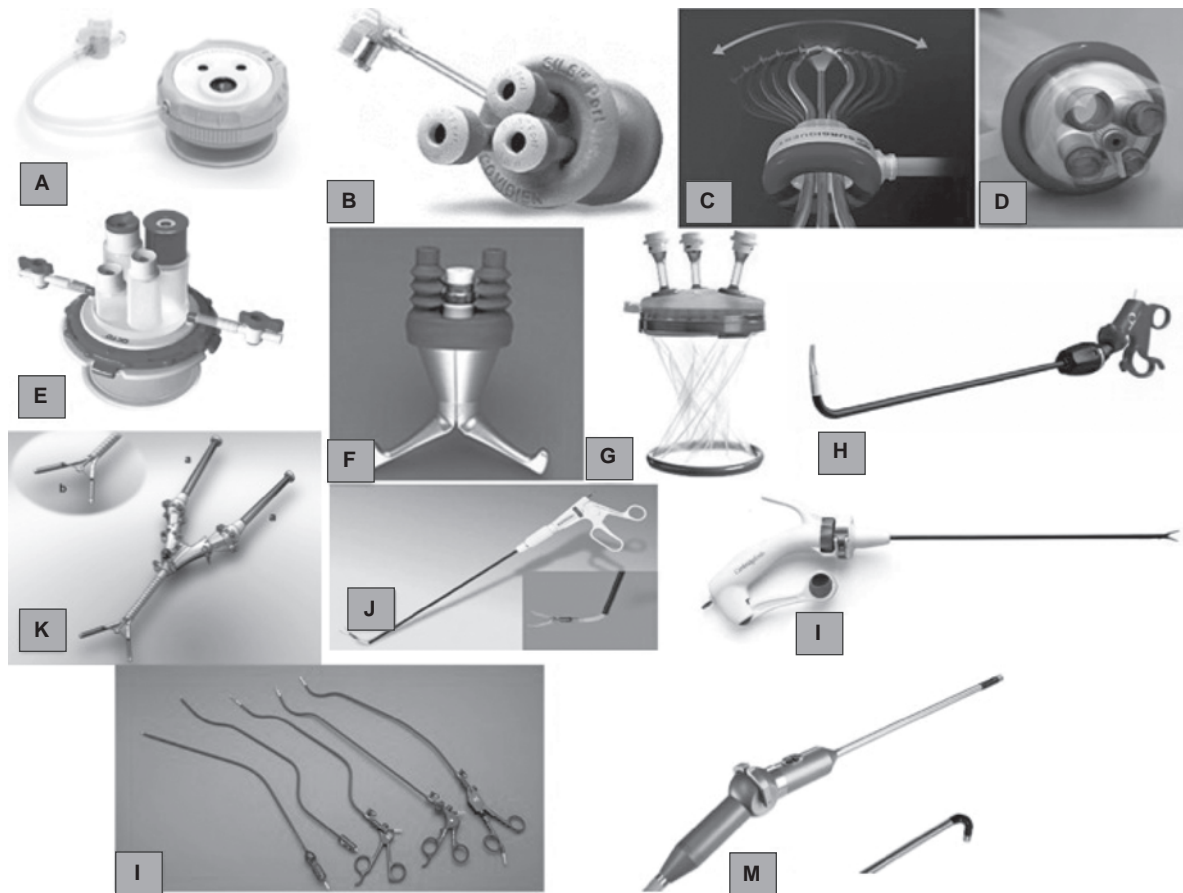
Specialized instruments for LESS (A-M), (A) Single Site Laparoscopy Access System (SSL) (Ethicon Endosurgery, Cincinnati, OH, USA); (B) Sils Port (Covidien, Mansfield, MA, USA); (C) Airseal (SurgiQuest, Orange, CT, USA); (D) Quadport (Olympus Medical, Orangeburg, NY, USA); (E) OCTO Port (DalimSurgNet, Seoul, South Korea); (F) X-cone (Karl Storz, Tuttlingen, Germany); (G) GelPOINT (Applied Medical, Rancho Santa Margarita, CA, USA); (H) Real Hand (Novare Surgical Systems, Cupertino, CA, USA); (I) Cambridge Lapro-angle (Cambridge Endo, Framingham, MA, USA); (J) Roticulator (Tyco Healthcare, Pleasanton, CA, USA), (K) SPIDER surgical system (TransEnterix, Durham, NC, USA); (L) S-Portal series (Karl Storz, Tuttlingen, Germany), (M) Ideal Eyes HD (Stryker, San José, CA, USA).
